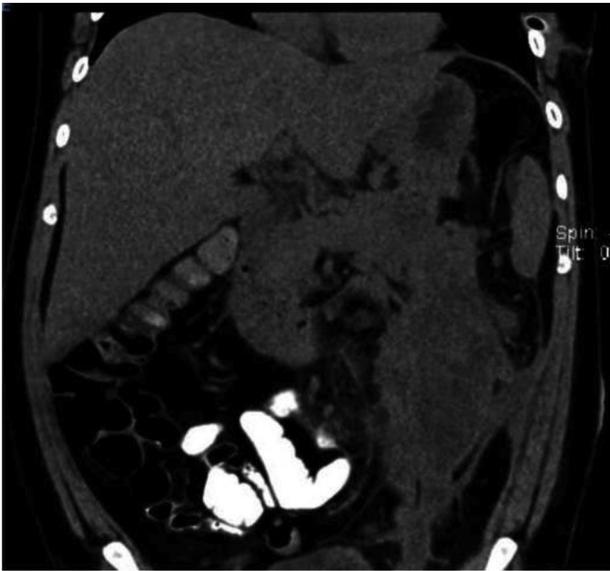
Computed tomography scan with contrast showing pancreatic necrosis and collections in the parietocolic gutter.
